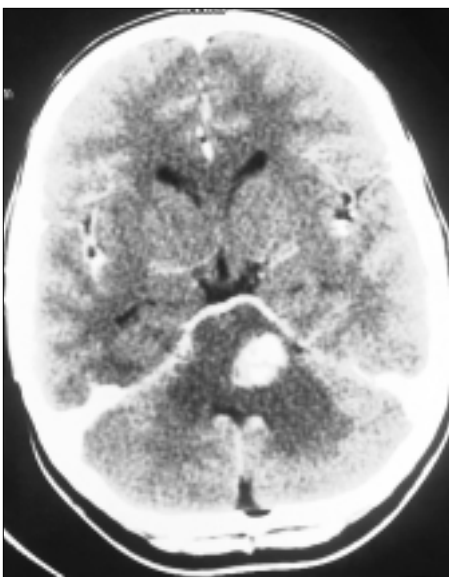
Contrast-enhanced CT of the head shows a densely enhancing pontine lesion extending into the midbrain.
